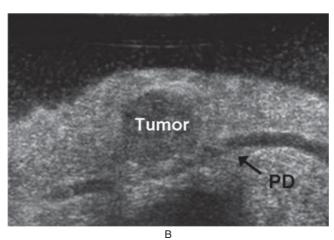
A. A pancreatic body tumor (*arrow*) is visible on the surface of the pancreas (uncommon). B. Intraoperative ultrasonography demonstrates close proximity of the pancreatic duct (PD) just deep to the tumor. C. The tumor is carefully enucleated without damage to the duct, and the patient is cured.
